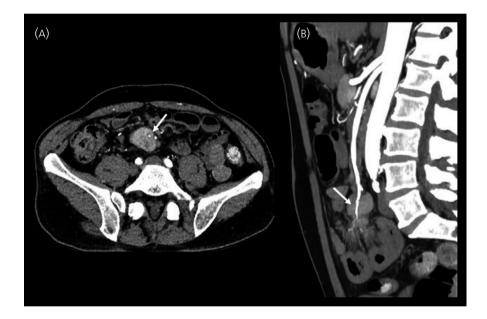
Transverse computed tomography images on arterial phase (A) with sagittal reconstruction using maximal intensity projection (B) show an involvement of the distal mesenteric artery branches (arrows) stage 2
